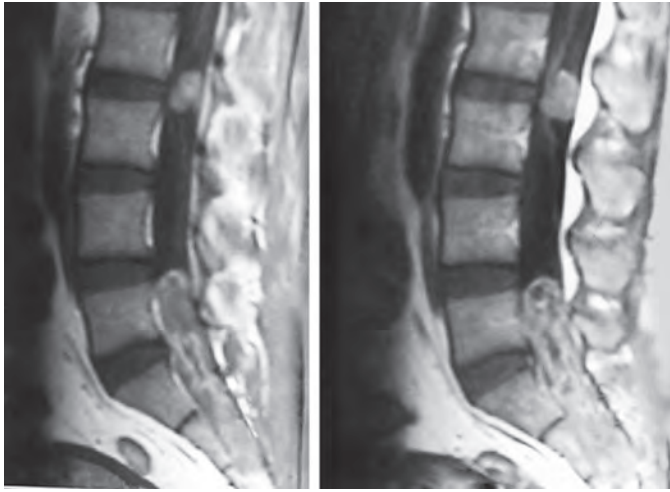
MRI lumbar spine (gadolinium-enhanced T1-weighted) showing intradural ependymomas at L2 and sacral regions
